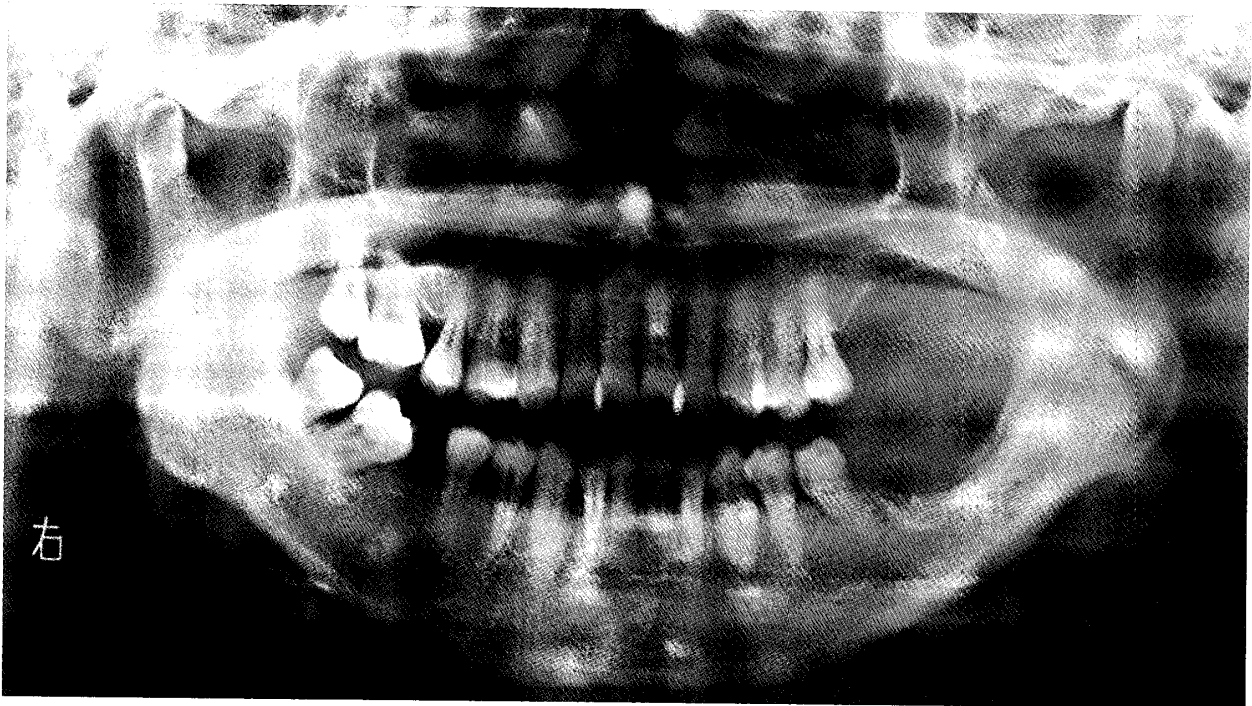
Panoramic radiography after 2 years and 6 months since the end of concurrent therapy.
